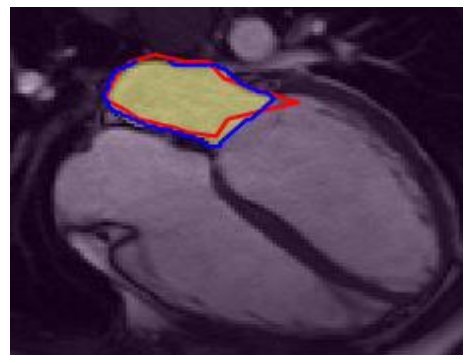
U-net+UKF prediction results in MRI sequences. For each image, the yellow area is the desired label and blue contour is the prediction results
